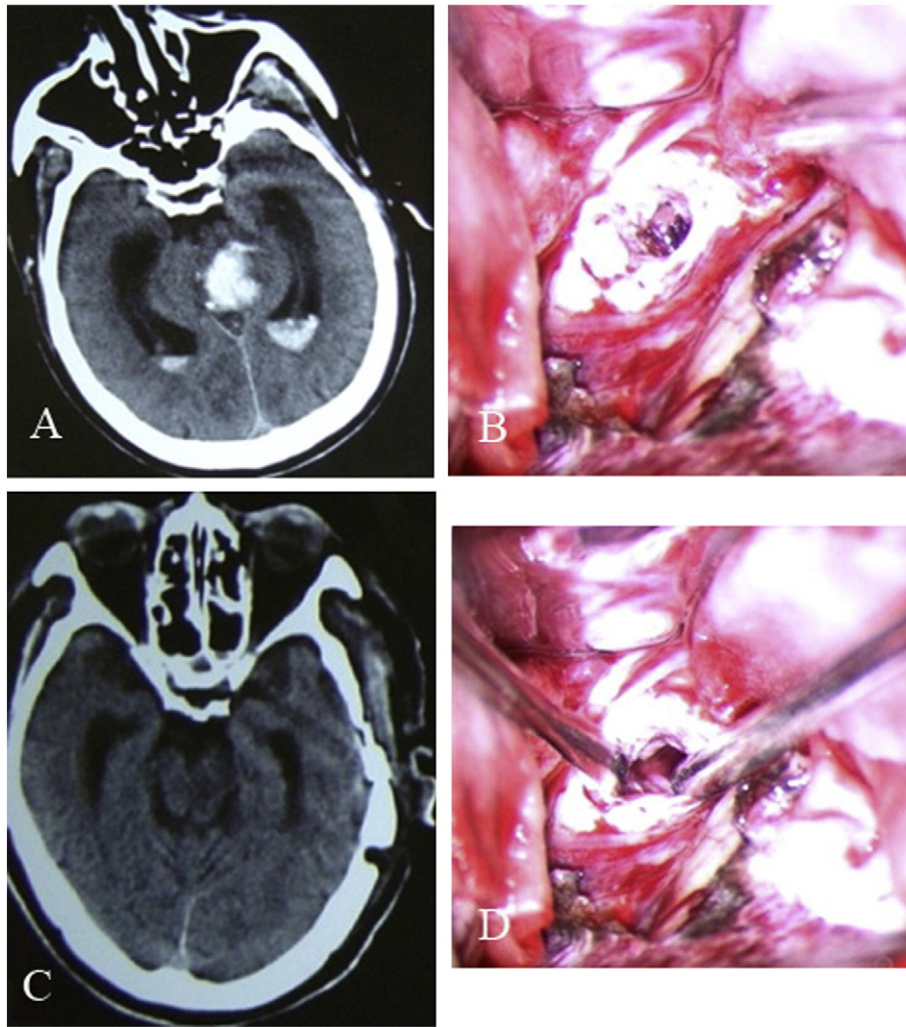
Left basal–tegmental pontine hemorrhage with fourth ventricular extension. (A) CT head showing the hyperdense hematoma at the postero–basal–tegmental area of pons invading the fourth ventricle. (B) Intraoperative view of hematoma. (C) Post-operative CT head showing the resolution of the hematoma with encephalomalacic changes. (D) Intraoperative view after complete removal of hematoma.
